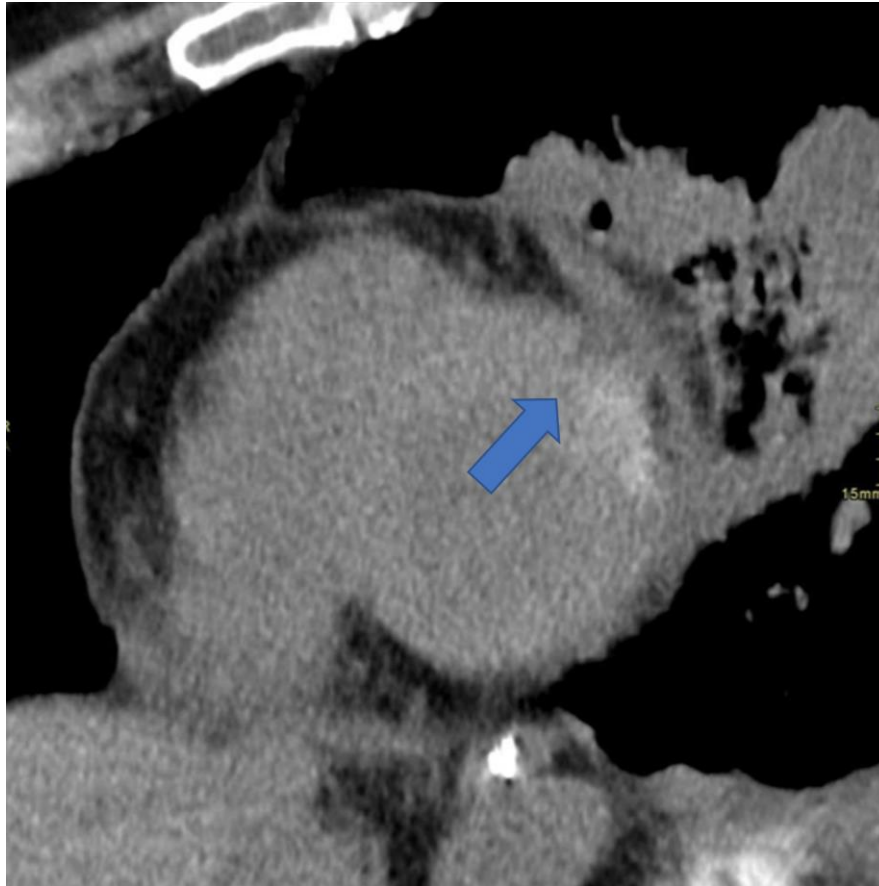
Sagittal view of Chest CT, detailed view of the heart showing close relation of the pulmonary consolidation with the heart (blue arrow).
